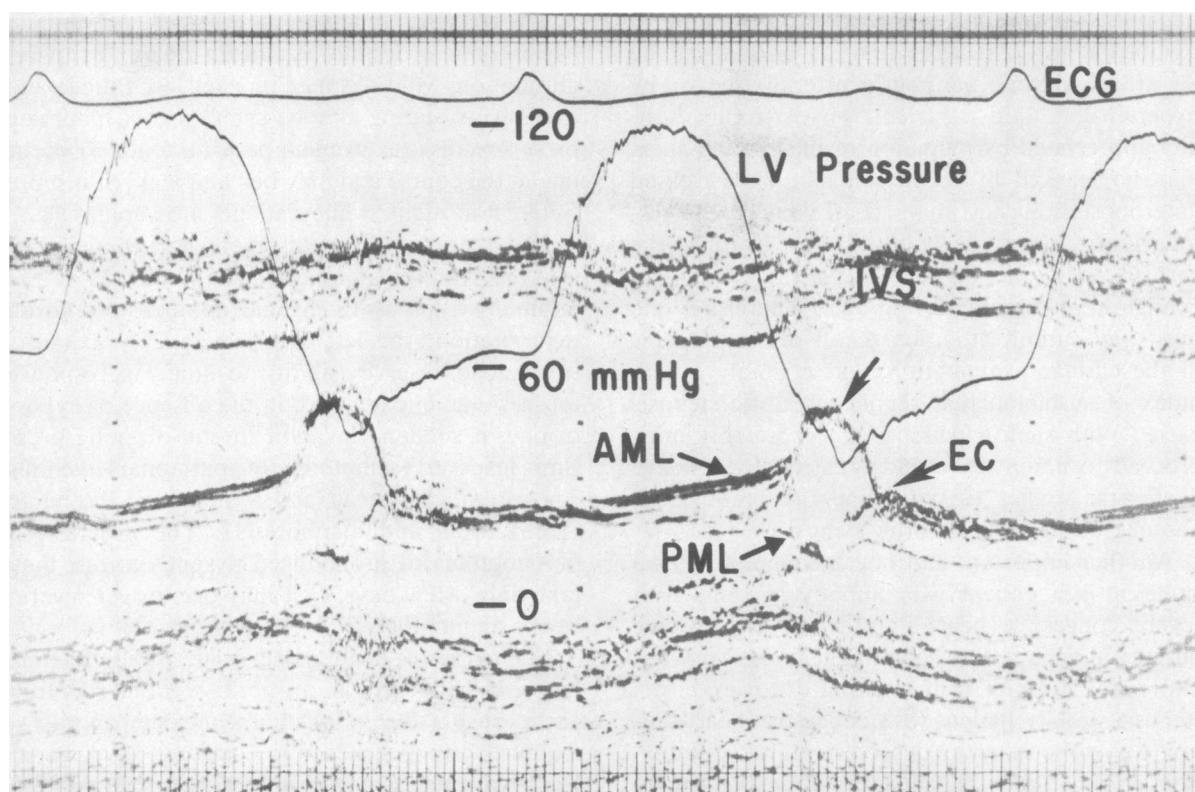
Echocardiogram of the mitral valve and simultaneous left ventricular pressure in a patient with acute aortic insufficiency due to endocarditis. AML=anterior mitral leaflet; PML=posterior mitral leaflet; IVS=interventricular septum. Diastolic fluttering of the AML is present (unlabeled arrow). Early closure (EC) of the mitral valve is apparent with notably elevated left ventricular diastolic pressure; aortic regurgitation continues but filling across the mitral valve occurs only early in diastole.
